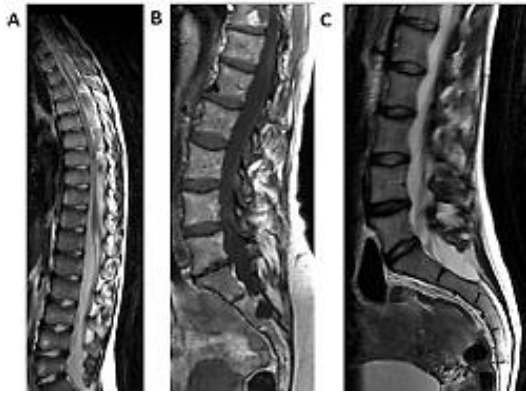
MRI images of dural ectasia. (a) Duralectasia grade 1, with a mean of dural saccimension values between 14 and 18 mm; (b)dural ectasia grade 2, with a mean of dural saccimension values greater than 18 mm and up to 20 mm; (c) dural ectasia grade 3, with values mean upper 20 mm, with anterior sacral meningocele.
